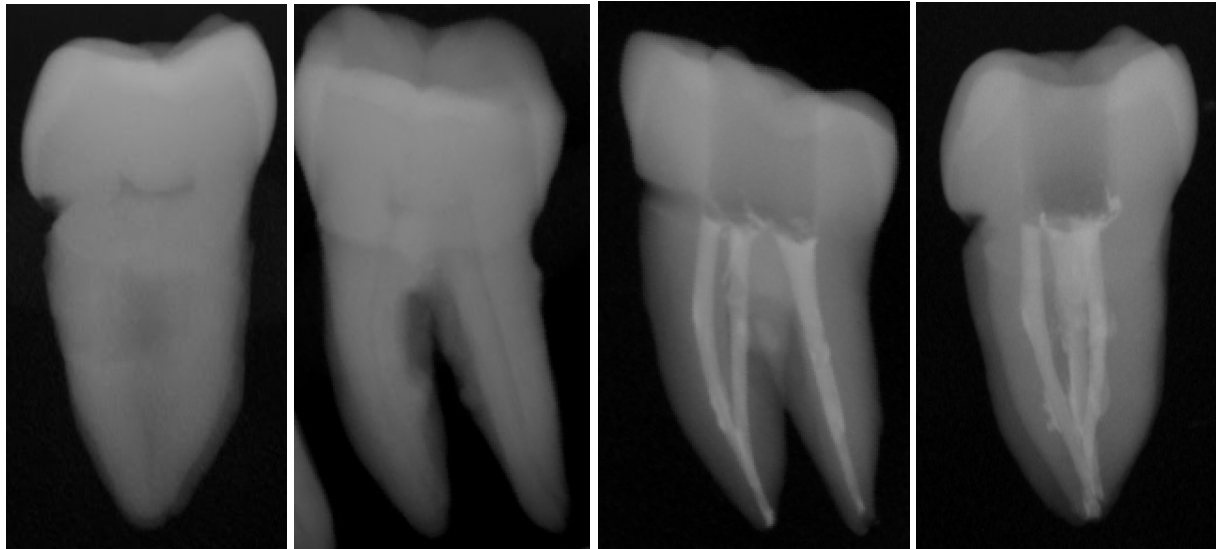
Periapical radiographs taken mesio-distally and bucco-lingually of a mandibular molar during screening and post-obturation with TSWV
